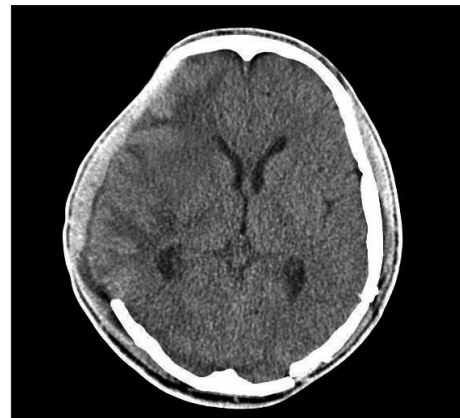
Initial computed tomography scan shows hemorrhagic contusion in the right fronto-temporo-parietal region with severe brain swelling and epidural hematoma in the left temporo-occipital region.
